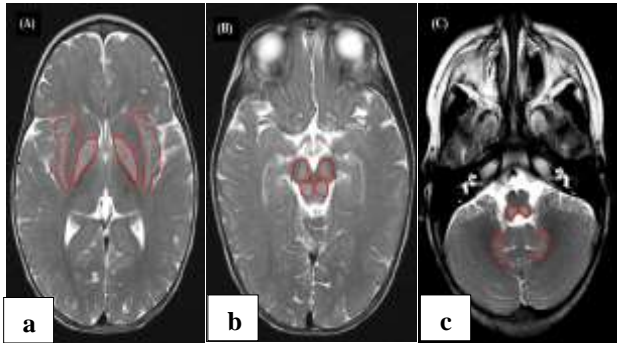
MRI Axial T2-weighted TSE (turbo spin echo) sequences of the brain showing multifocal enhancement outlined in red: (a) symmetric T2 hyperintensity of the bilateral globi pallidi, external capsules, and claustra; (b) symmetric T2 hyperintensity throughout the midbrain; and (c) symmetric T2 hyperintensity of the dorsal medulla and dentate nuclei.
